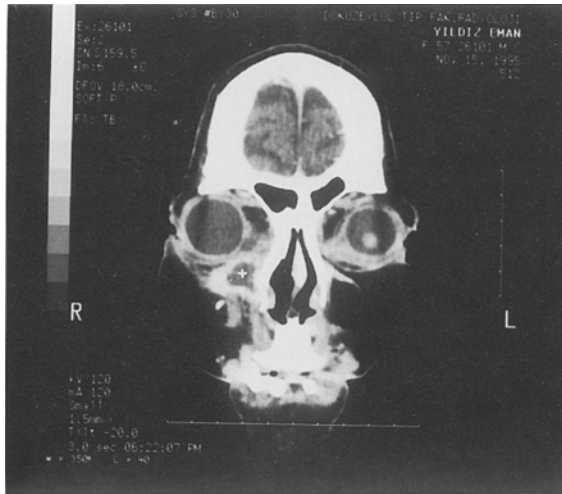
Coronal enhanced orbital CT scan of a 57-year-old woman. A lesion is seen in the inferomedial part of the right orbit (cursor). The lesion shows a low density and demonstrates marked rim enhancement. Note also the extensive soft tissue changes around the right eye, indicative of infection.
